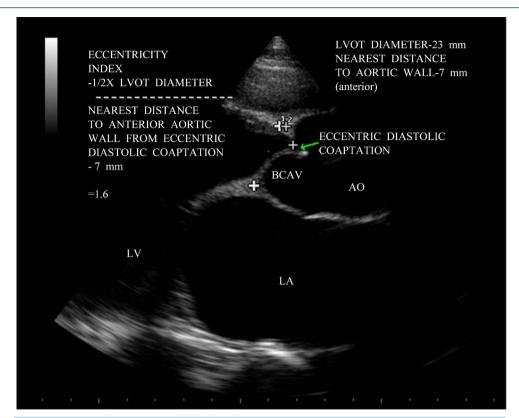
Parasternal long axis view showing the "eccentricity index".
